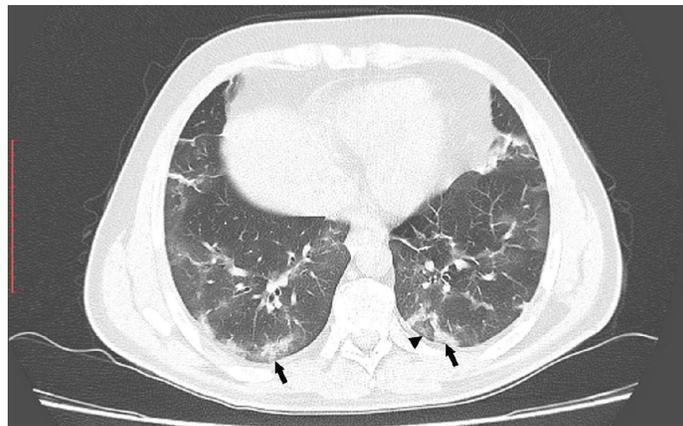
A case of COVID-19 pneumonia confirmed by RT-PCR. 34-year-old man, day 1 after symptom onset, with moderate severity criteria. Axial chest CT shows multiple peripheral ground-glass opacities (arrowheads) bilaterally. Time to conversion (i.e. time interval to have a negative PCR): 45 days.
